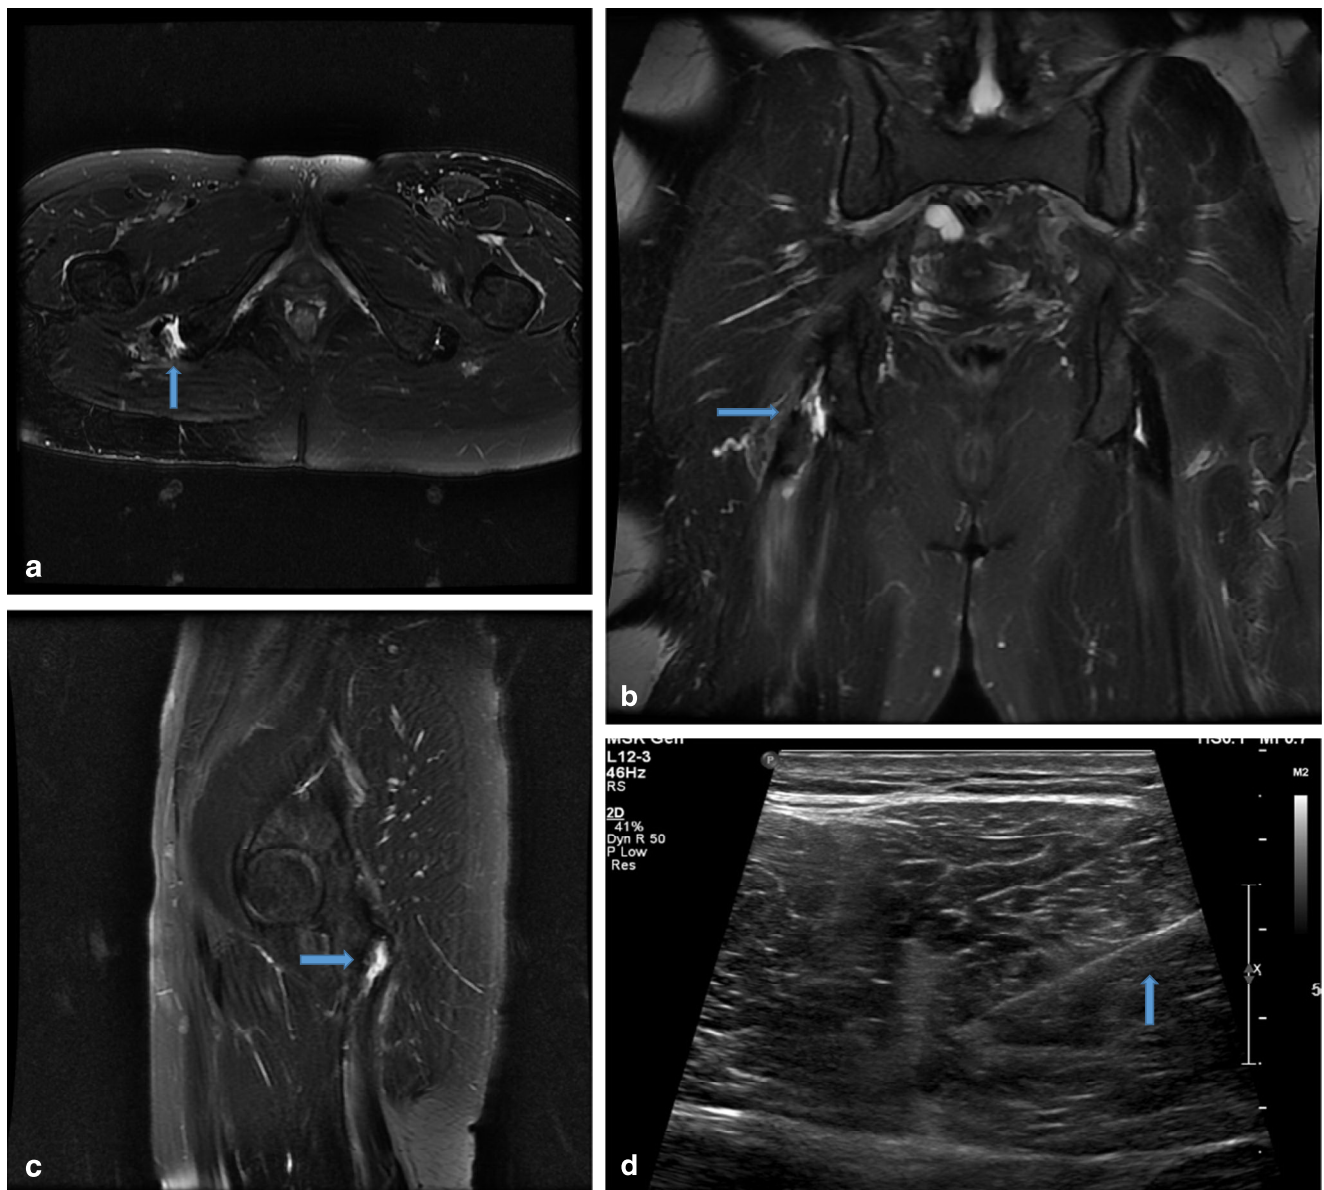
a Axial short tau inversion recovery (STIR) sequence MRI of the thighs in a 28-year-old male with grade 2 injury of the right semimembranosus tendon at the proximal attachment site demonstrating muscle edema and fluid (*blue arrow*). b Coronal STIR sequence MRI of the thighs in the same patient with grade 2 injury of right semimembranosus tendon at the proximal attachment site demonstrating
